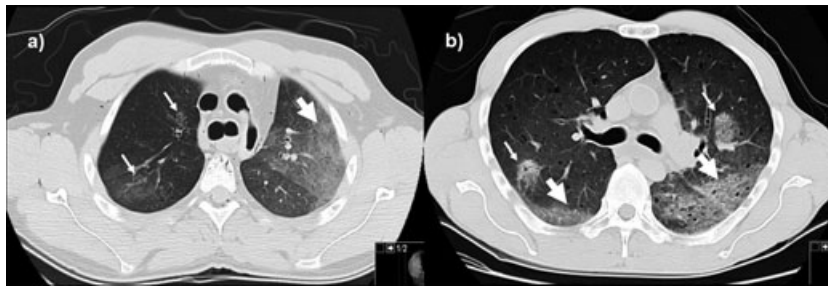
Pulmonary imaging findings in two cases (n. 33 [a] and n. 36 [b]) with anterograde aspiration of minimal severity. A transverse multislice computed tomography image shows rounded areas of ground-glass opacity in the right lung (a) and in both lungs (b) (thin arrows), associated with large homogeneous areas of increased density (bold arrows) in dependent regions. These were attributed to inner livores based on the position of the body after death. Note the greater density of gradient densities in the image in (b), which was obtained a longer period of time after death than the image in (a).
